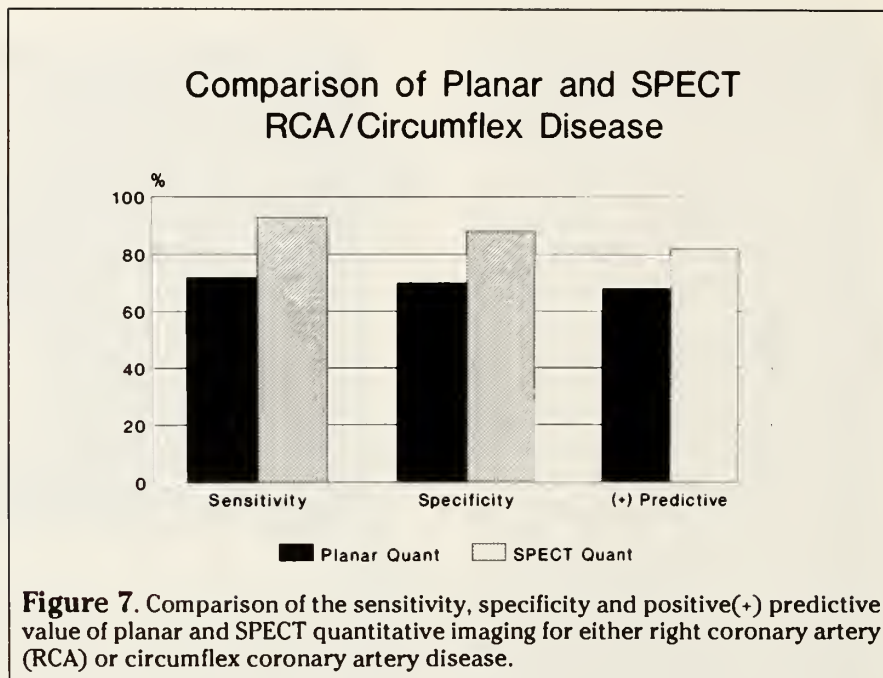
Comparison of the sensitivity, specificity and positive(+) predictive value of planar and SPECT quantitative imaging for either right coronary artery (RCA) or circumflex coronary artery disease.
